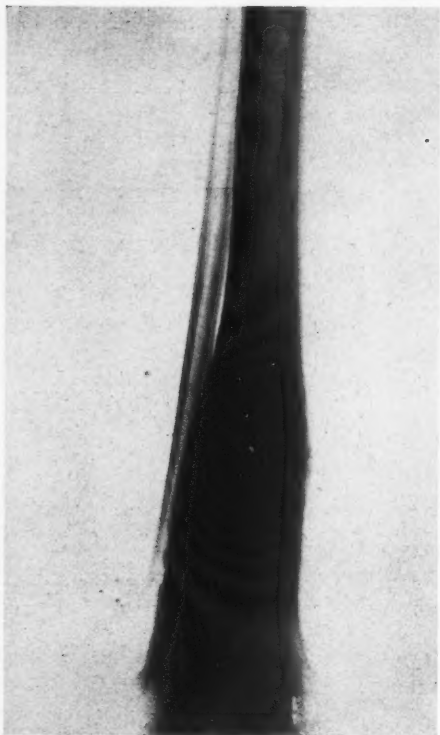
Roentgenogram of the lower tibia of a patient with Garre's osteitis. There is a diffuse ossifying lesion of the shaft with sclerosis of cortical and cancellous bone and roughening of the periosteum. Note the spindle-shaped swelling produced by the widening of the shaft.
